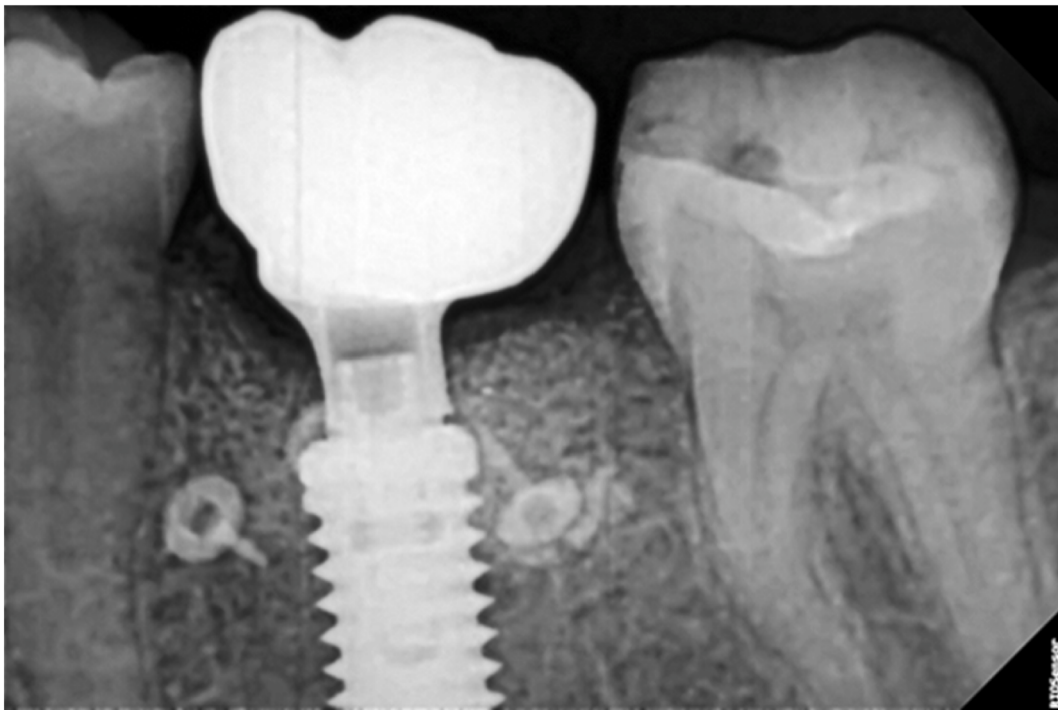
Follow up periapical radiograph at 7 months shows adequate crestal bone stability.
